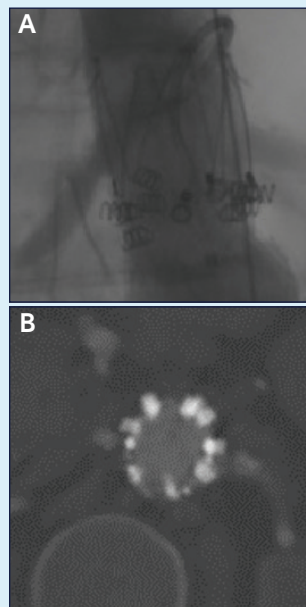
Intraoperative (A) and CT (B) images show adventitial penetration of EndoAnchors into the aortic wall.
